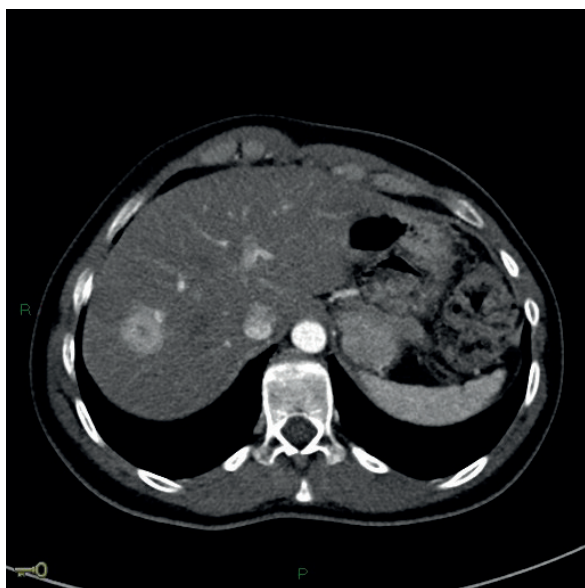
CT evaluation. Contrast-enhanced computed tomography image showing a nodular 18 mm lesion with increased vascularity.
